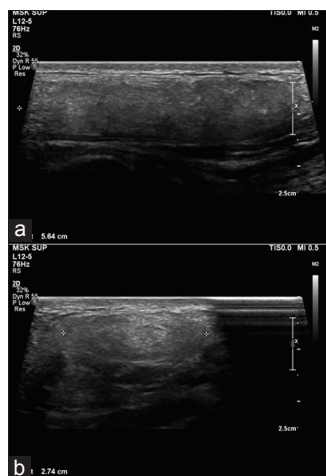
Longitudinal (a) and transverse (b) ultrasound images of elongated chord-like hyperechoic lesion on anterolateral aspect of leg, ankle, and foot showing few hypoechoic linear areas
